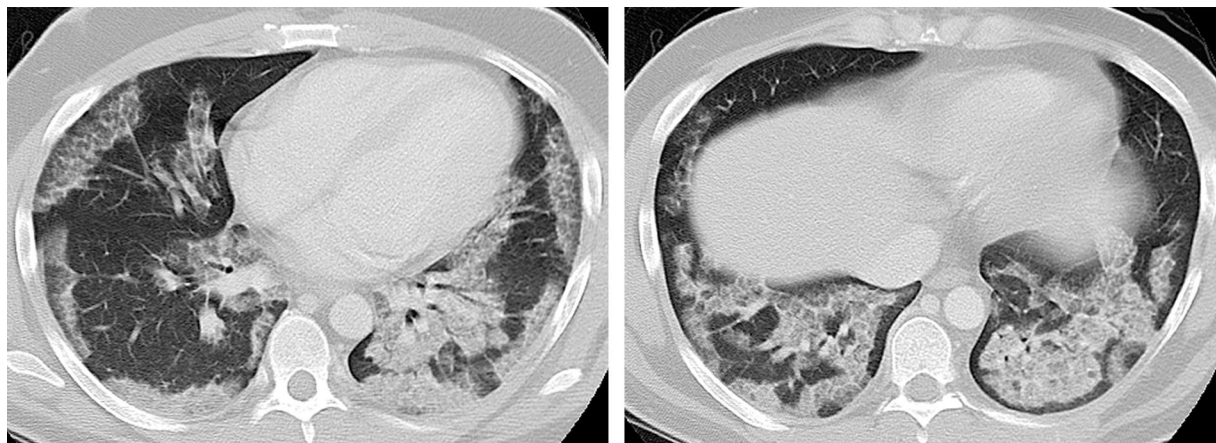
Secondary alveolar proteinosis following stem cell transplantation. CT scans obtained at different levels show geographically distributed ground-glass attenuation and interlobular septal thickening.
